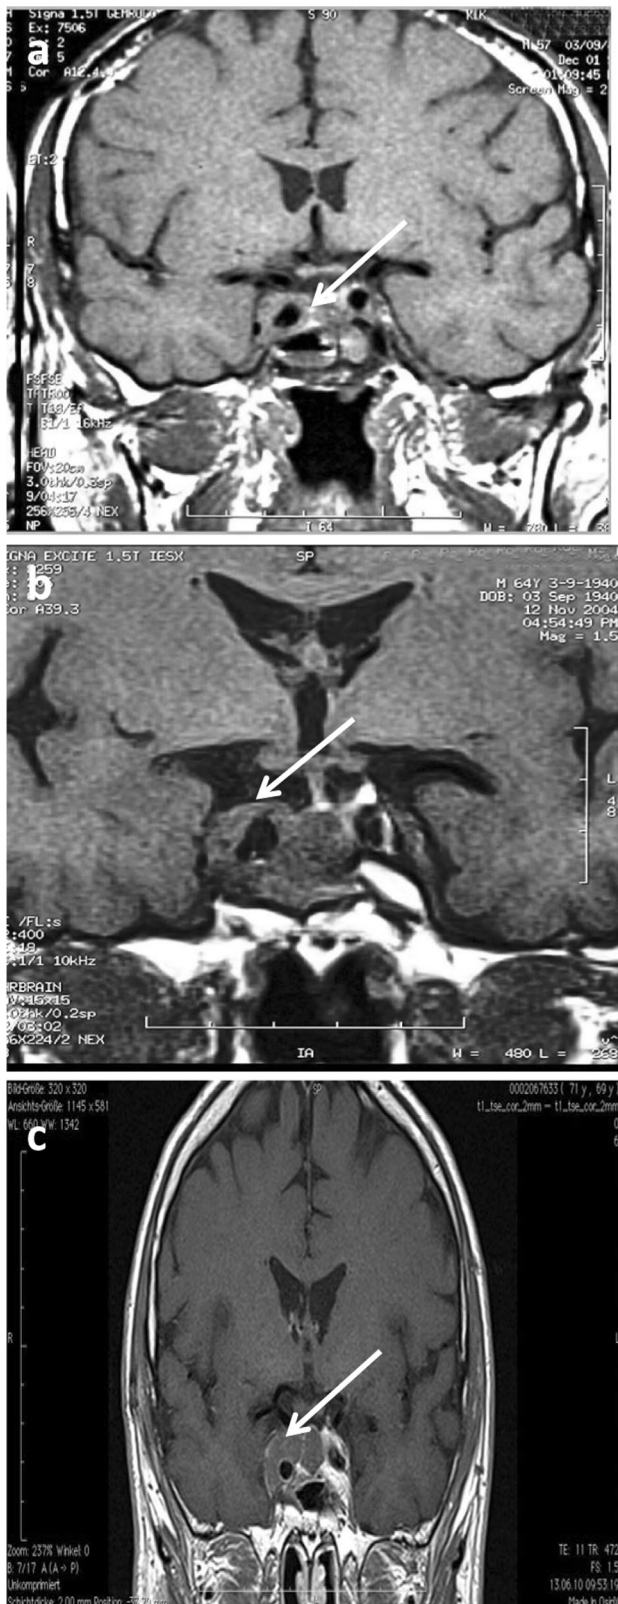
Contrast coronal magnetic resonance imaging (T1WI) after transsphenoidal surgery in 1996 (a) and at the time of N. oculomotorius palsy in 2004 (b). Following surgery there is residual tumor within the sinus cavernosus right (a arrow) and the remaining intact pituitary gland is on the left. During follow-up residual tumor within the sinus cavernosus right increases in size resulting in N. oculomotorius palsy (b arrow). Last magnetic resonance imaging in 2011 showing stable residual mass in the right sinus cavernosus (c arrow)
